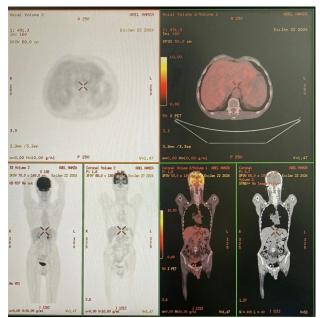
A 45-year-old man with normal weight underwent PET-CT. (A) 3D PET; (B) axial tomographic slice at the level of the liver.
